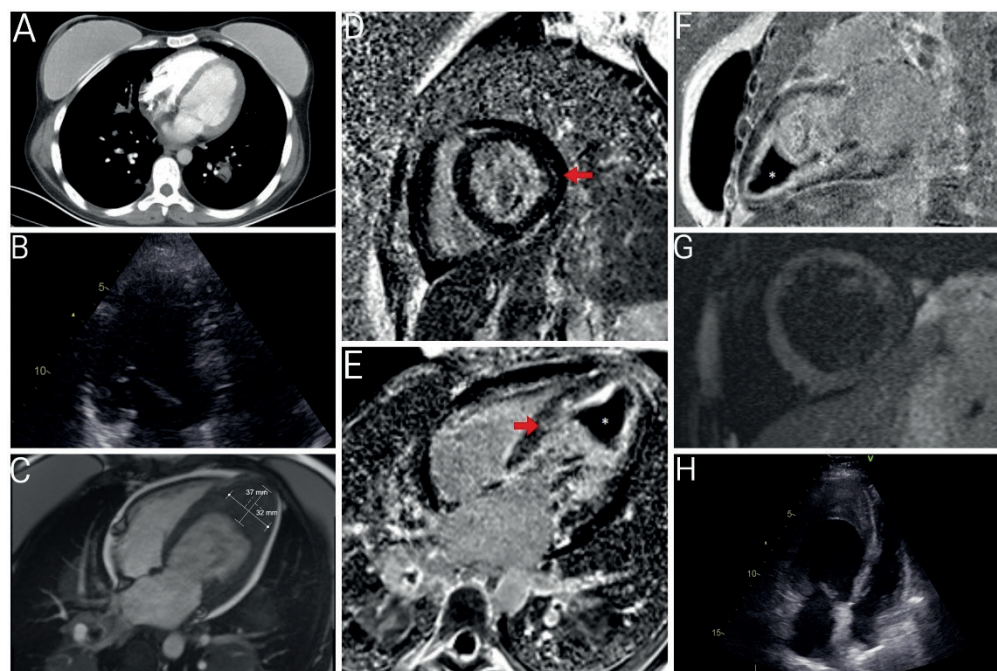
A) Computed tomography angiography image on the first day, no thrombus was observed in the left ventricle (LV); B) First transthoracic echocardiography (TTE) four-chamber view, no thrombus in the LV; C) Cardiac magnetic resonance (CMR) four-chamber view demonstrating thrombus; D) CMR short axis view demonstrating myocardial late gadolinium enhancement (LGE), marked with a red arrow; E) CMR four chamber view demonstrating subendocardial and myocardial LGE marked with a red arrow and * showing the thrombus; F) CMR sagittal view demonstrating subendocardial and myocardial LGE and * showing the thrombus; G) CMR STIR short-axis view showed signal increase consistent with myocardial inflammation; H) TTE four-chamber view demonstrating a filling defect suggestive of a thrombus was detected in the LV apex.
